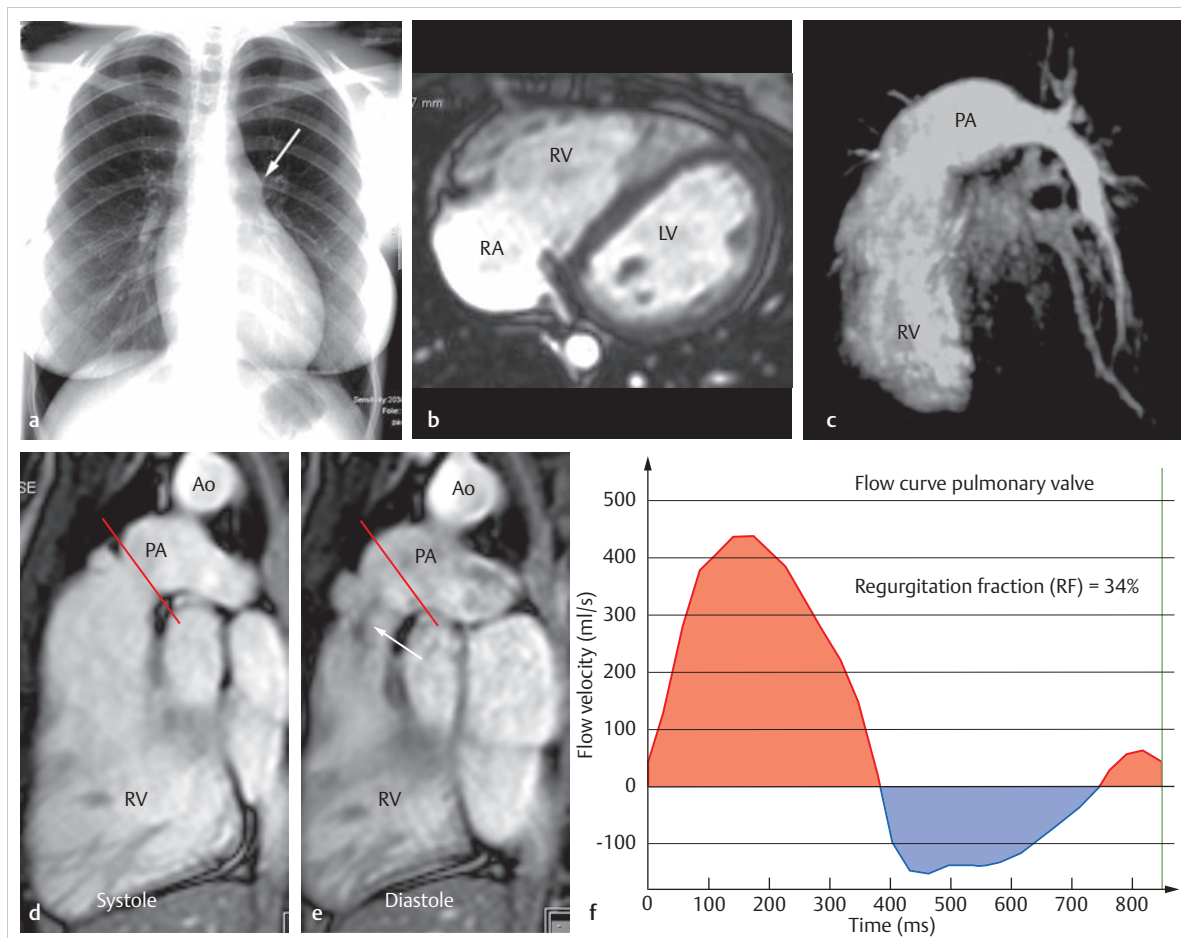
Condition after a commissurotomy of a pulmonary valve stenosis. Various depictions of a 14-year-old girl's condition after a commissurotomy of a pulmonary valve stenosis during her first year of life. Now, only residual pulmonary valve insufficiency remains. Using MRI flow measurement in the "in-plane" (along the course of the vessel; d, e) and "through-plane" (perpendicular to the course of the vessel or cranial and parallel to the valve level; d, e, red line, cross-sectional plane for g-i) phase contrast techniques, pulmonary valve insufficiency can be quantified precisely as a regurgitation fraction in ml or in % (f; 34% in this case).
